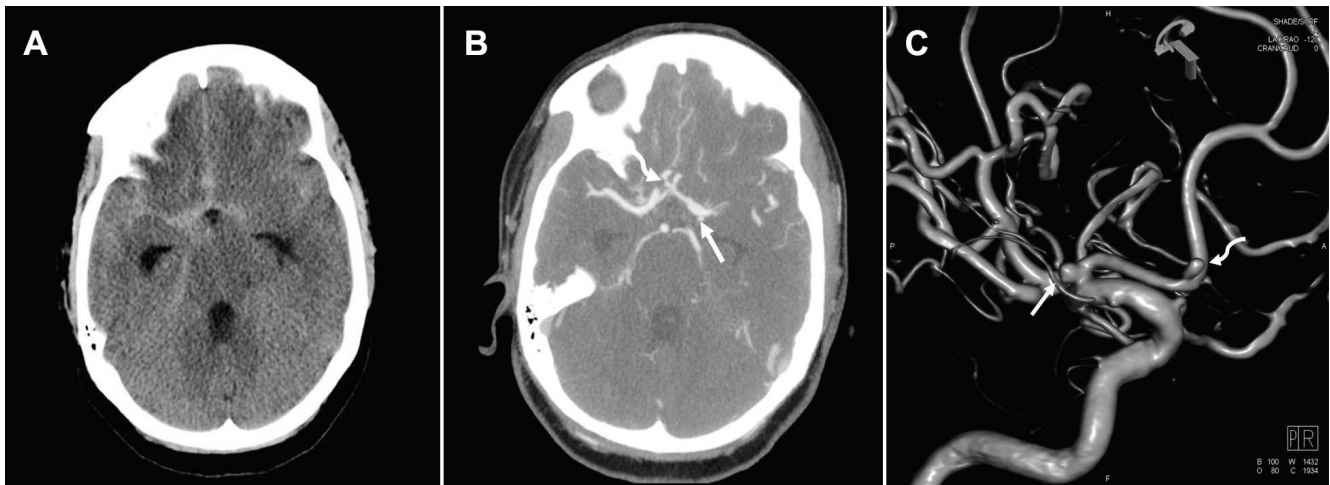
A: Axial noncontrast computed tomography (CT) demonstrates a sizable volume of subarachnoid hemorrhage centered in the suprasellar cistern with extension into the interhemispheric fissure and Sylvian fissures. B: Axial maximum intensity projection reconstruction from a corresponding CT angiogram shows 2 aneurysms arising from the left anterior cerebral artery (straight arrow and curved arrow). C: Three-dimensional reconstruction from a follow-up catheter-based digitally subtracted angiogram shows the proximity of the 2 lesions (straight arrow and curved arrow).
